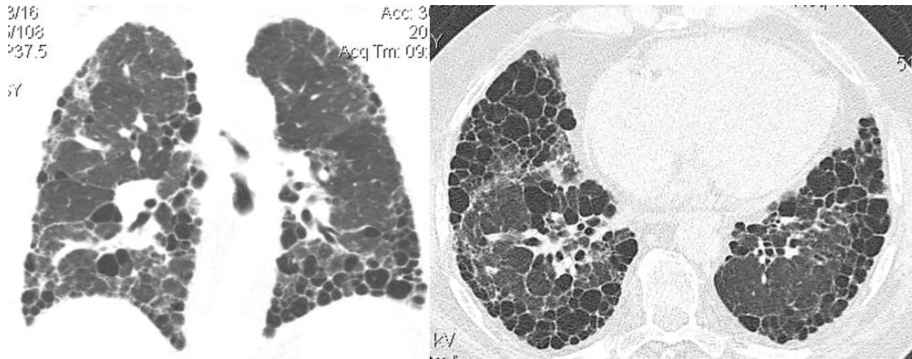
Massive lung fibrosis in a patient with anti-MPO-ANCA vasculitis in remission (frontal and axial CT images), with honeycombing appearance.
